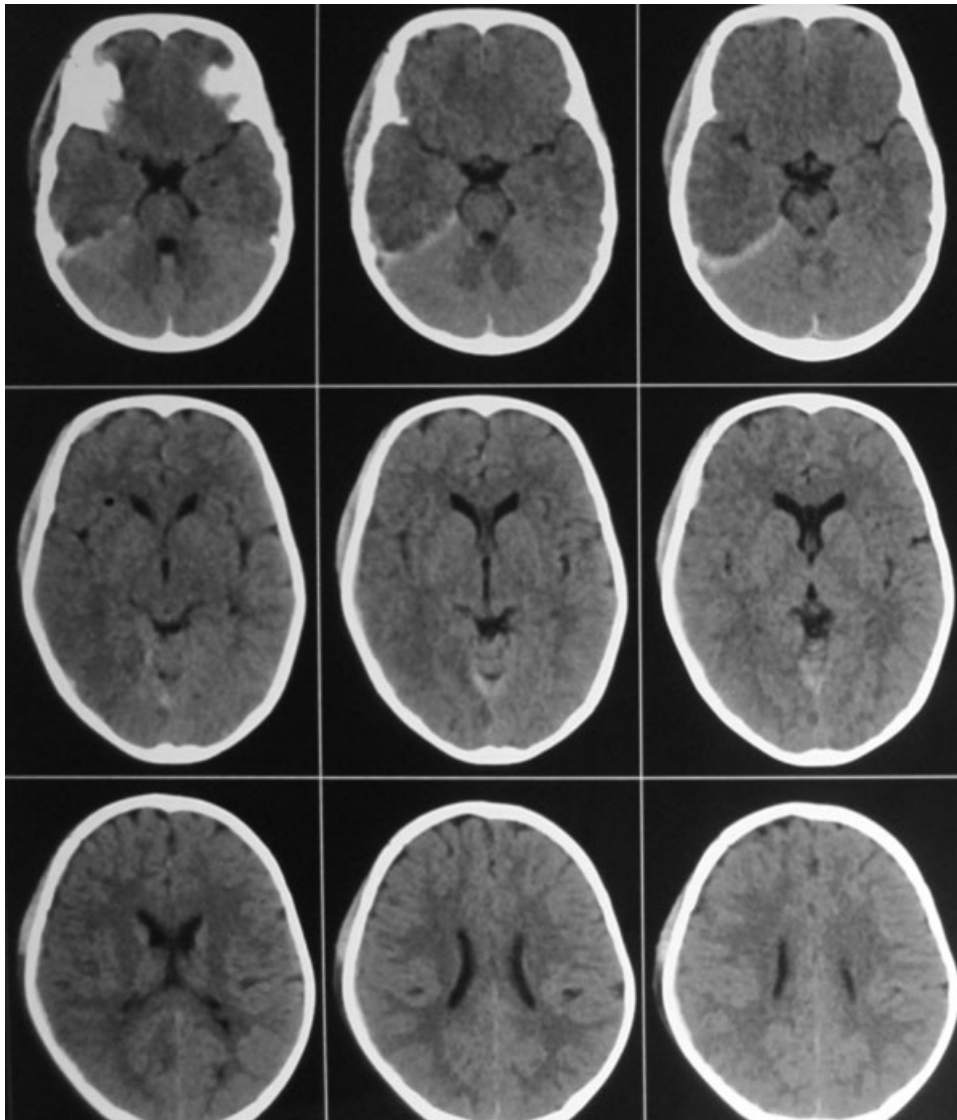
CT brain plain done 9 hours later showing resolution of acute SDH. CT, computed tomography; SDH, subdural hematoma.
